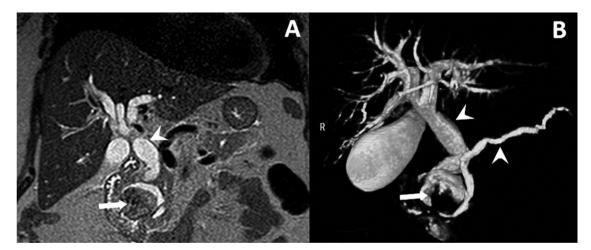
(A) T2-weighted coronal MR images of the abdomen and (B) MRCP with maximum intensity projection (MIP) demonstrated improved visualization of the dilated intra and extrahepatic bile ducts and pancreatic duct (arrow heads) caused by duodenal diverticulum (white arrow).
